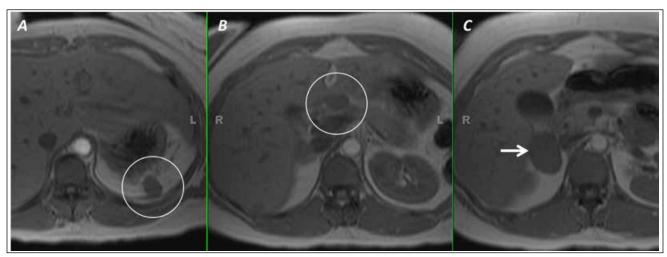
Axial T1-weighted gradient echo magnetic resonance imaging (cranial to caudal) demonstrates (A) left subphrenic nodule, (B) peripancreatic nodule, and (C) right suprarenal mass.
